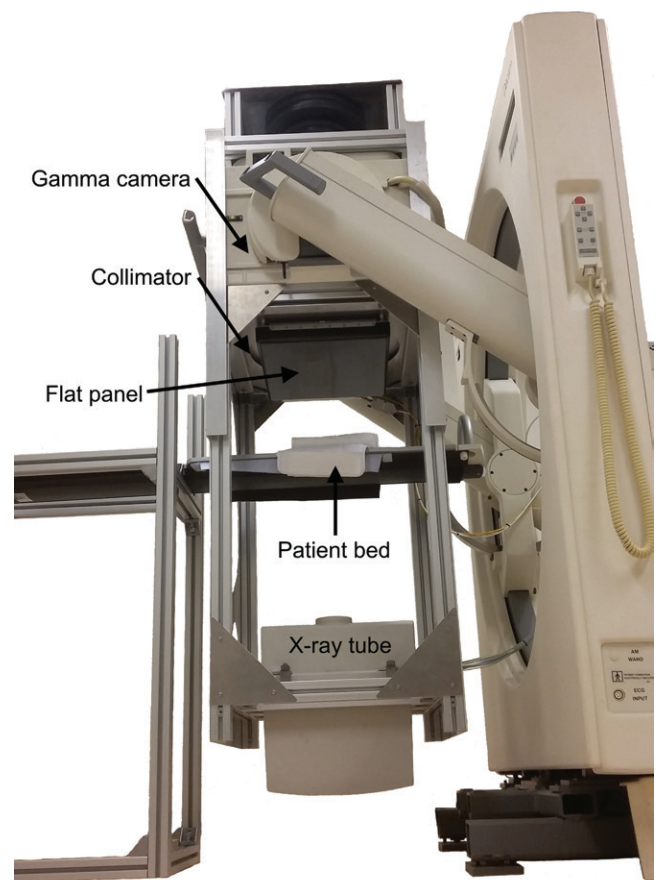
Prototype setup consisting of a γ camera with cone beam collimator (focus at 98 cm), modified flat panel, and x-ray tube.
